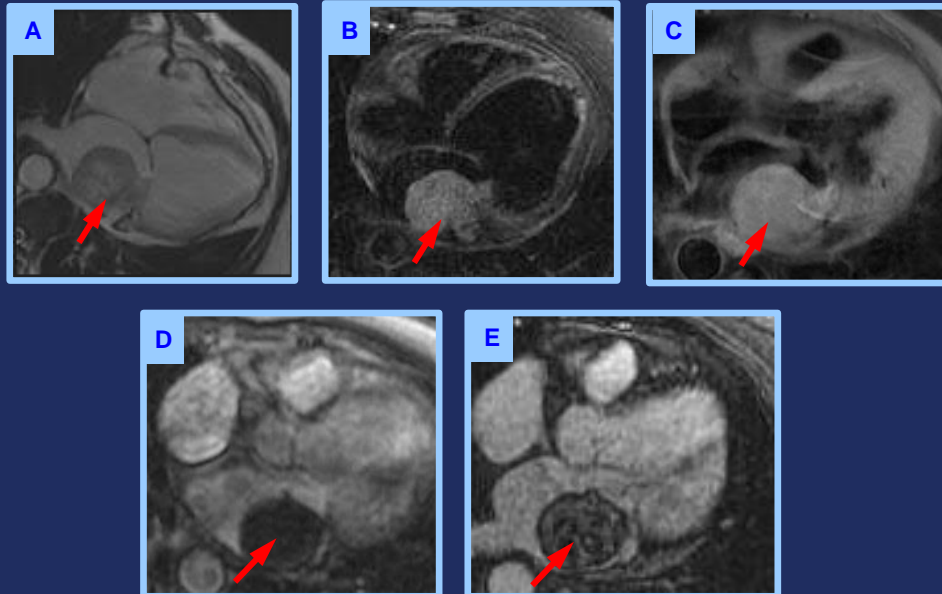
A) SSFP cine frame in horizontal long axis plane demonstrating a 5.4 X 5.2 cm mass attached to the posterior wall of the left atrium. It is iso-intense to the myocardium with heterogeneous signal intensity, and obstructs the mitral valve. B) It is hyperintense on T2-weighted imaging suggestive of increased water content. C) It continues to be hyperintense on fat suppression images, making it unlikely to be a lipoma. D) On perfusion images, it does not enhance with contrast. E) Heterogenous enhancement of the mass on late gadolinium enhancement makes it inconsistent with thrombus.
